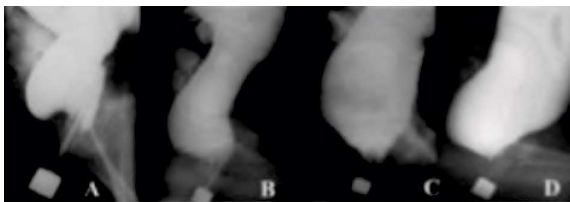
Radiographs of the anorectal area of children with functional constipation. The true diameter of the marker is 1.6 cm. On all pictures the horizontal branch of the rectum is absent, as its vertical branch is greatly expanded compared to the age norm. A. The length of the RND is 3.5 cm (normal maximum length of the anal canal at the age of three years is 2.8 cm); B. The length of the anal canal is within the age limit, but barium penetrates into the anal canal behind the tip of the enema as a result of weakness of the PRM; C and D. Significant expansion of the rectum is combined with a sharp shortening of the anal canal and insufficiency of the PRM.
